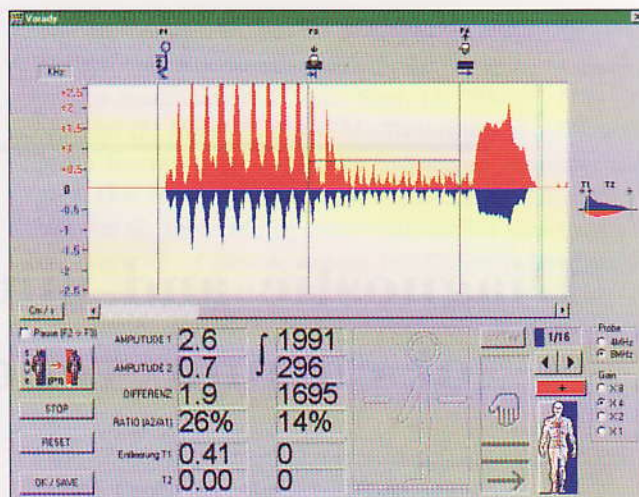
Functional Doppler curve of extensive varicosis with valve insufficiency.
